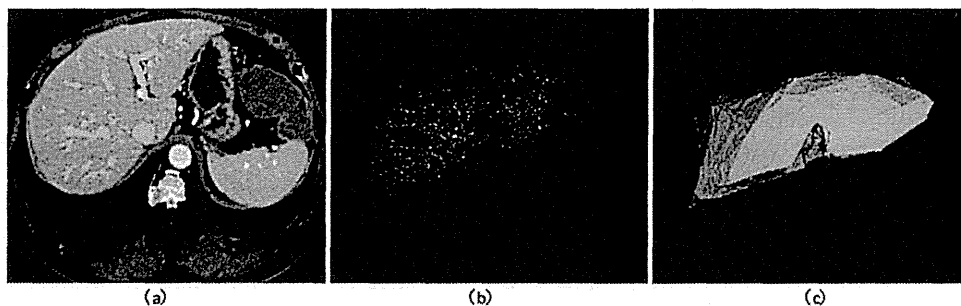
Example of constructing the polyhedron structure of a liver core region using HBVs and intensity: (a) preprocessed CT dataset (without enhancement) and extracted HBVs, (b) extracted end points of HBVs, and (c) constructed polyhedron structure of the core region.
